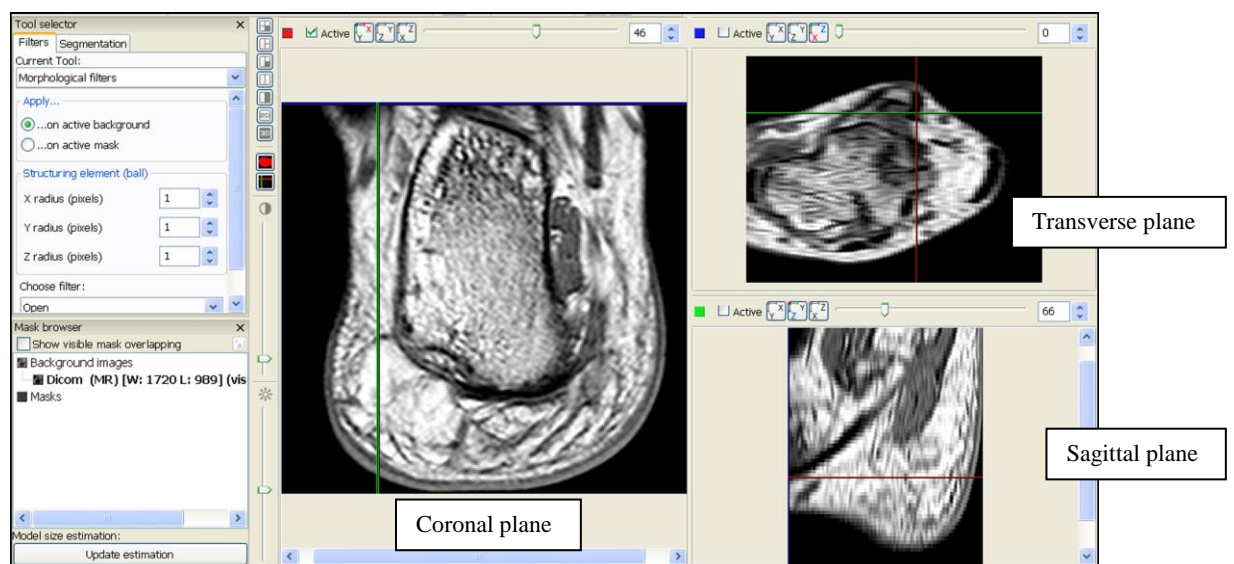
The MRI data in three views.
